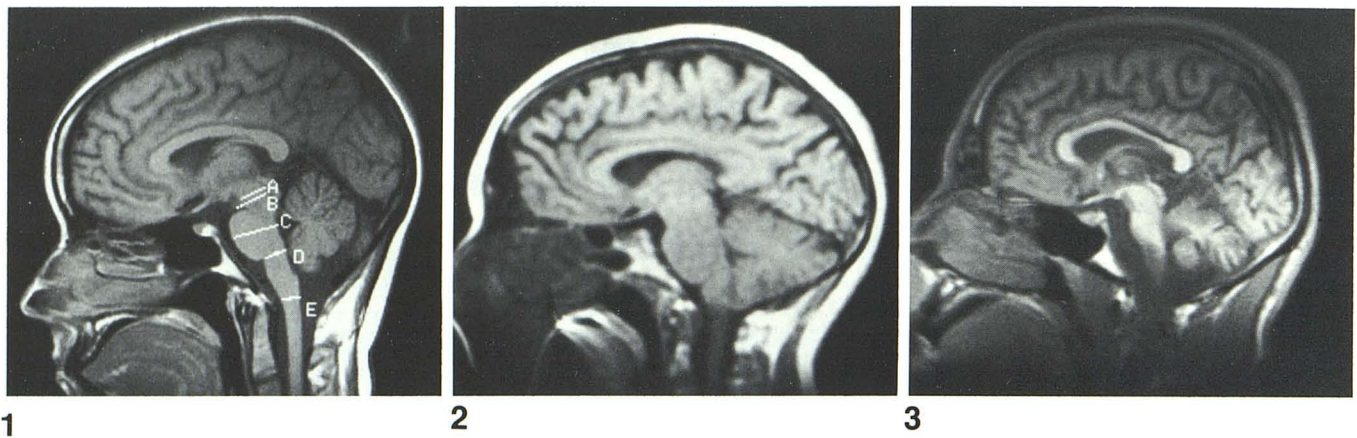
Sagittal MR image showing diameters measured.
